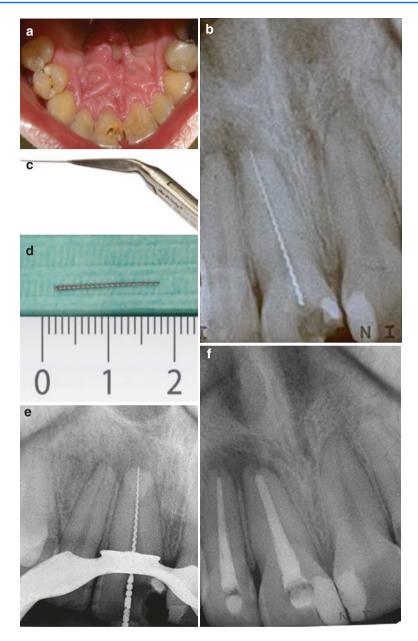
(a, b) Clinical and radiographic examination revealed access cavity with no temporary filling in the right maxillary central incisor and a fragment of an endodontic instrument extending from the coronal orifice to the apex "covering" approximately the whole length of the root canal. The treating dentist left the access cavity unsealed and invited his patient to "clean" the canal with an instrument he had given her nearly a year before when she began treatment with him. She had fractured the instrument within the canal 3 months earlier, and since then, she had started taking antibiotics repeatedly (amoxicillin 625 mg \times 3) for 4 days each time. (c, d) The fragment was retrieved with forceps. (e, f) Instrumentation, calcium hydroxide dressing for 10 days, and obturation of the root canal with the cold lateral compaction technique of gutta-percha and 811 sealer (Roth International Ltd., Chicago, IL, USA) followed (Courtesy of Dr. M. Kasambali)
